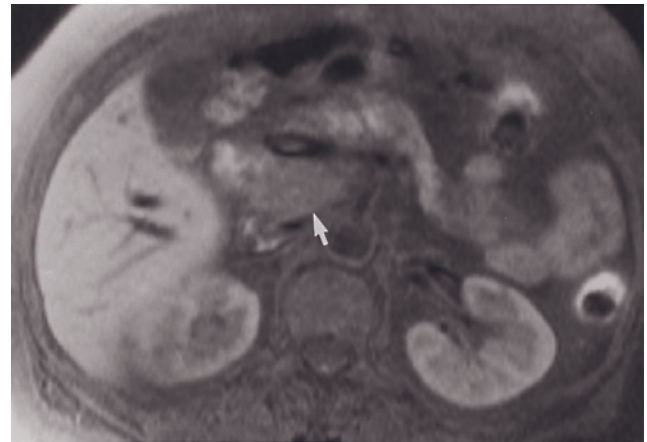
Insulinoma. T2-weighted ETSE (*a*), T1-weighted SGE (*b*), T1-weighted fat-suppressed SGE (*c*), immediate postgadolinium T1-weighted SGE (*d*), and 90-s postgadolinium fat-suppressed SGE (*e*) images. A 1-cm tumor (arrow, *c*) arising in the superior aspect of the midbody of the pancreas is isointense on T2 (*a*) and T1 (*b*)-weighted images and low signal on T1-weighted fat-suppressed image (*c*) and enhances intensely and homogeneously (arrow, *d*) on the immediate postgadolinium image. The lesion fades to isointensity with background pancreas (*e*).
